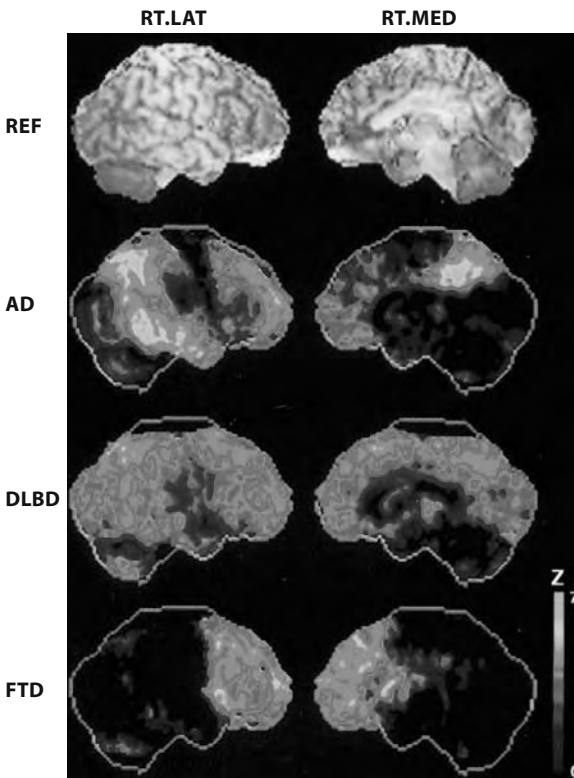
Stereotaxic surface projection maps of glucose metabolism deficits in patients with dementia. Two columns of images are presented, representing the lateral (*left column*) and medial (*right column*) surface projections of the right cerebral hemisphere. The *top row* demonstrates surface-rendered MRI of a normal subject for anatomic reference (*REF*). The other rows of images depict stereotaxic surface projections of cerebral glucose metabolic decreases in individual demented patients, displayed in Z-score scale in comparison to an elderly normal database. The *second row* depicts a typical AD patient with prominent temporo-parietal and prefrontal hypometabolism on the lateral projection, and posterior cingulate hypometabolism on the medial projection. The *third row* depicts deficits in an autopsy-proven case of diffuse Lewy body disease (*DLBD*) with reductions in the association cortical areas as in AD, but with additional involvement of the occipital cortex on both medial and lateral projections. The *bottom row* depicts deficits in a patient with isolated frontal lobe hypometabolism (frontal lobe dementia, *FTD*). The metabolic decreases are depicted in Z-scores (standard deviations from normal) according to the color scale on the *right*, extending from 0 to 7. From FREY et al. 1998
